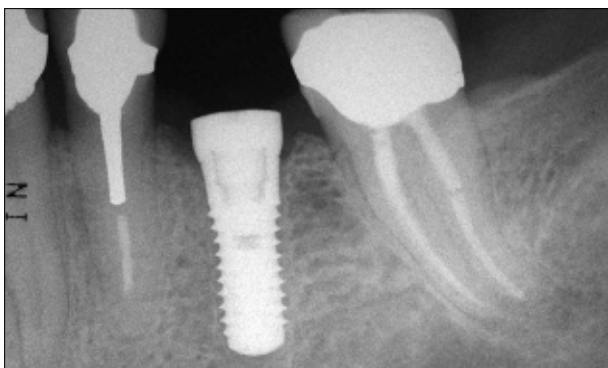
Radiograph of the implant at site 35 taken 1 month after surgery.
